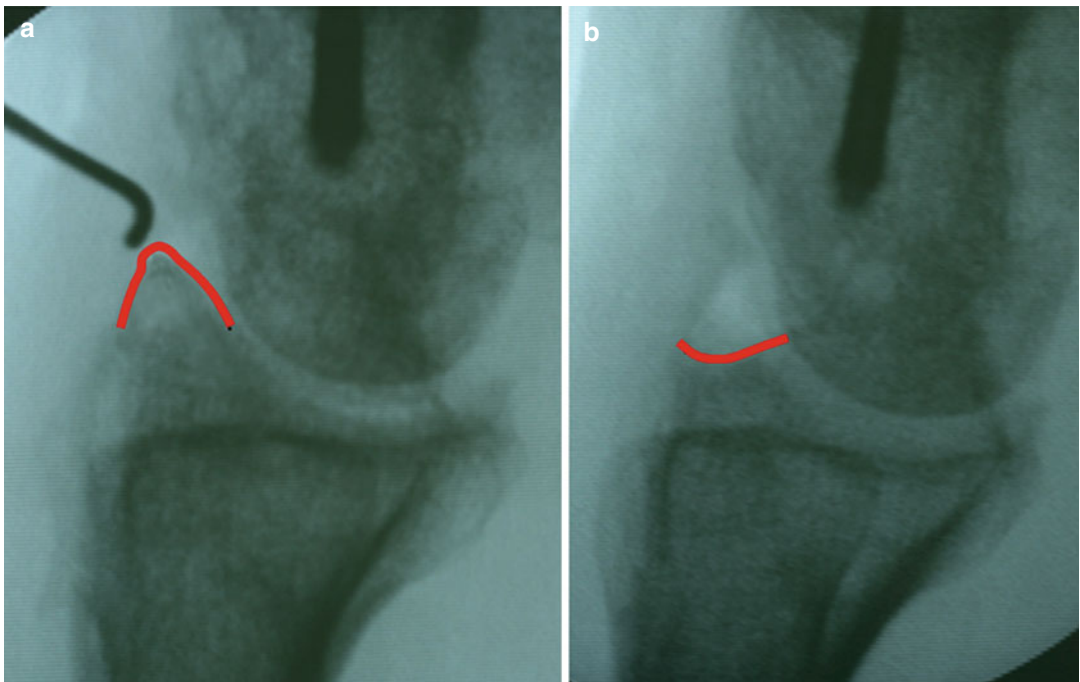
Lateral radiograph of a wrist showing dorsal impingement (arrow) of the distal radius following malunion of a fracture. (a) Before and (b) after arthroscopic debridement of dorsal rim (Courtesy of Francisco del Piñal)
